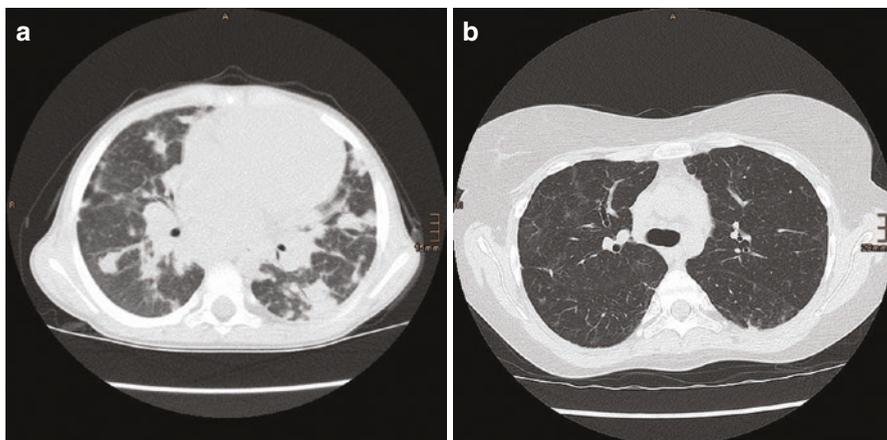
(a) Chest CT of a 6-year-old boy with CTLA-4 deficiency. Multiple round infiltrates resembling reversed halo (or atoll) signs as evidence of granulomatous-lymphocytic lung disease. (b) Chest CT of a 23-year-old woman with CTLA-4 deficiency. Mosaic attenuation and bronchiectasis
